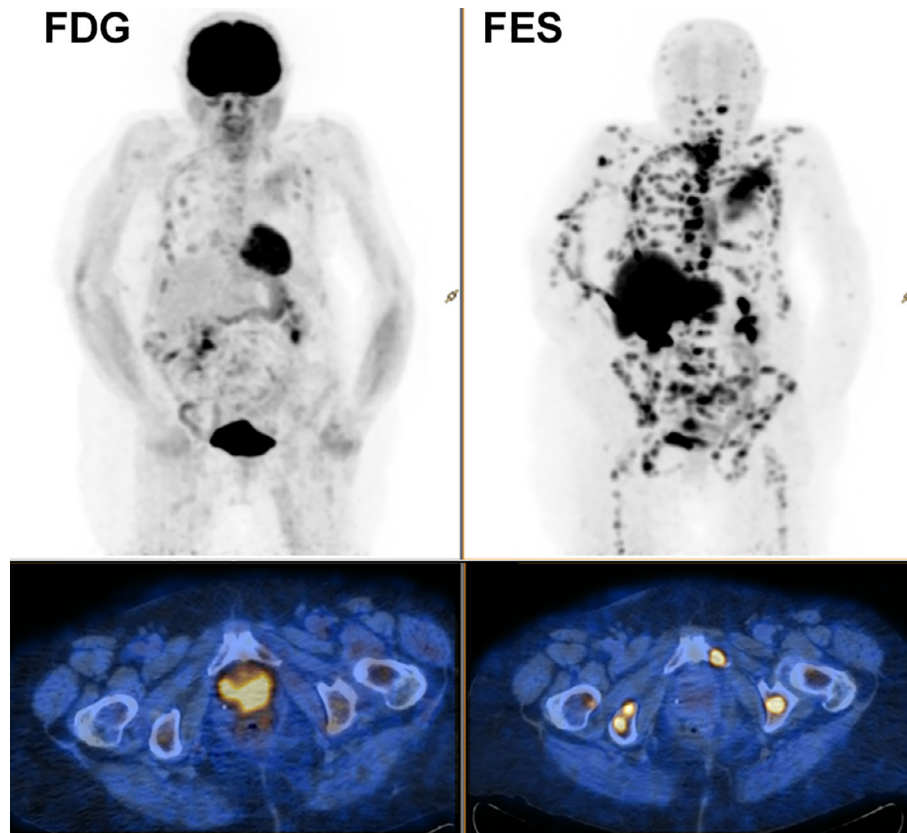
Transaxial pelvic (at the level of the pubic symphyses) positron emission tomography (PET)/computed tomography fusion images (^{18}F -FDG [left] and ^{18}F -FES [right]). The insets represent the whole-body PET image, of a patient with metastatic lobular ductal carcinoma of the breast. Note that ^{18}F -FDG uptake in many lesions is less than corresponding ^{18}F -FES uptake. Abbreviations: ^{18}F -FDG, ^{18}F -fluorodeoxyglucose; ^{18}F -FES, 16α - ^{18}F -fluoro- 17β -estradiol.
